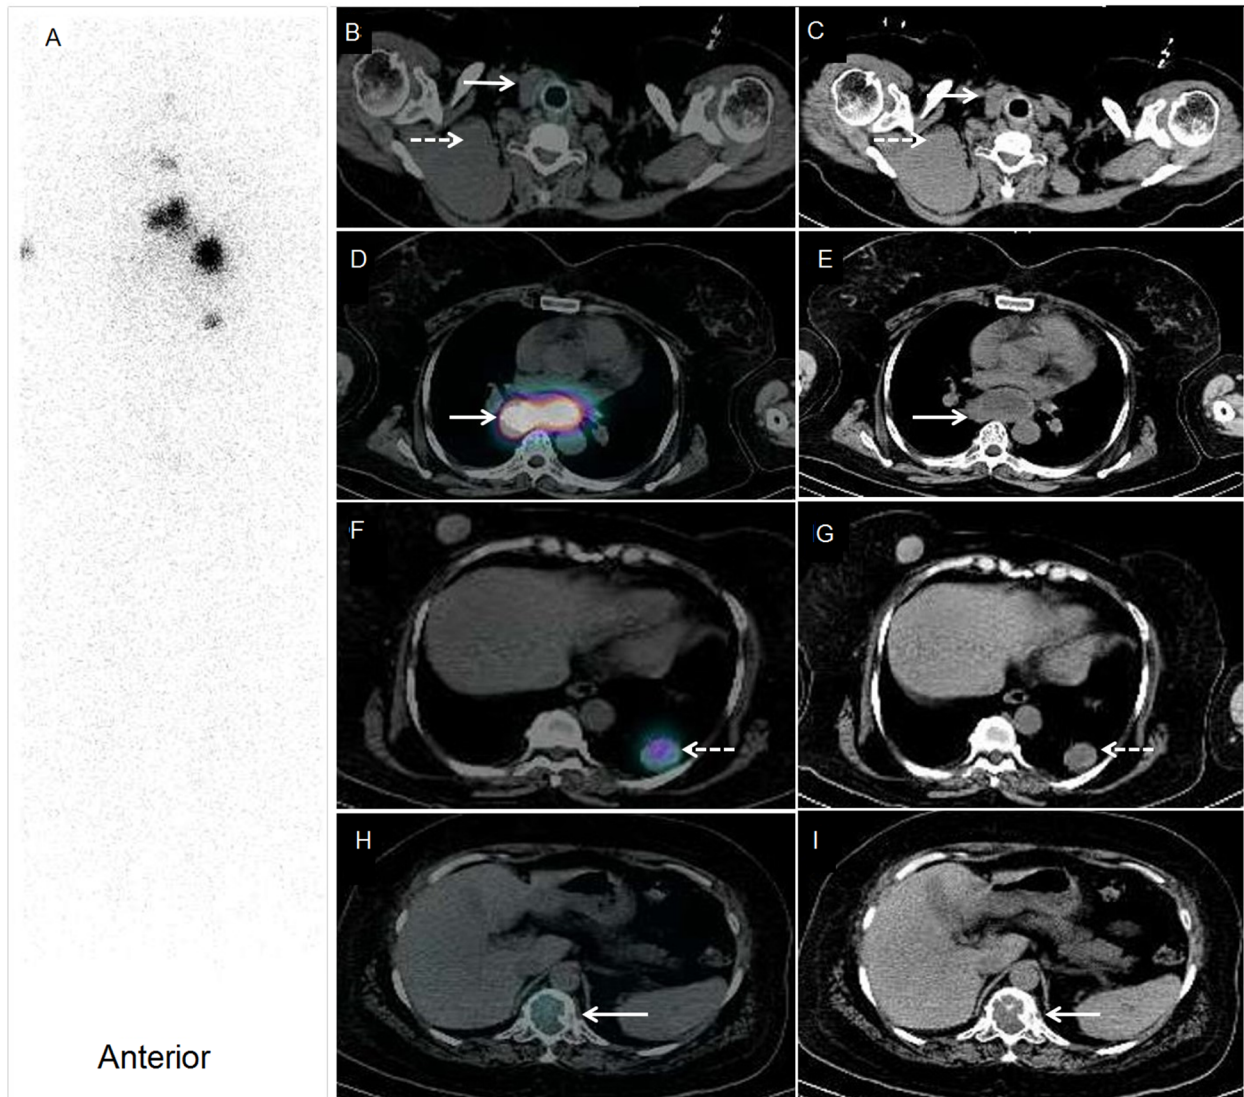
Whole-body radioiodine planar (a), transaxial SPECT/CT and CT images showing iodine-avid residual tissue in thyroid bed (b,c; solid arrow), multiple cervical and mediastinal lymph nodes (d,e), bilateral lung nodules (f,g), with few non-tracer avid cervical lymph nodes (b,c; dotted arrow), right breast (f,g) and skeletal (h,i) lesions.
